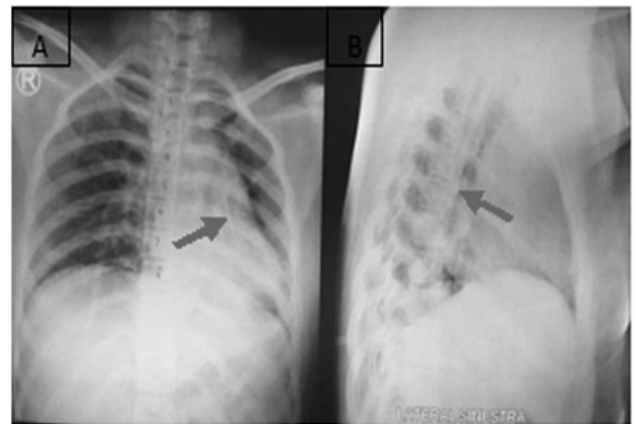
Plain chest radiograph after rigid bronchoscopy. A. Anteroposterior, B. Lateral. Arrows indicate foreign needle objects.
